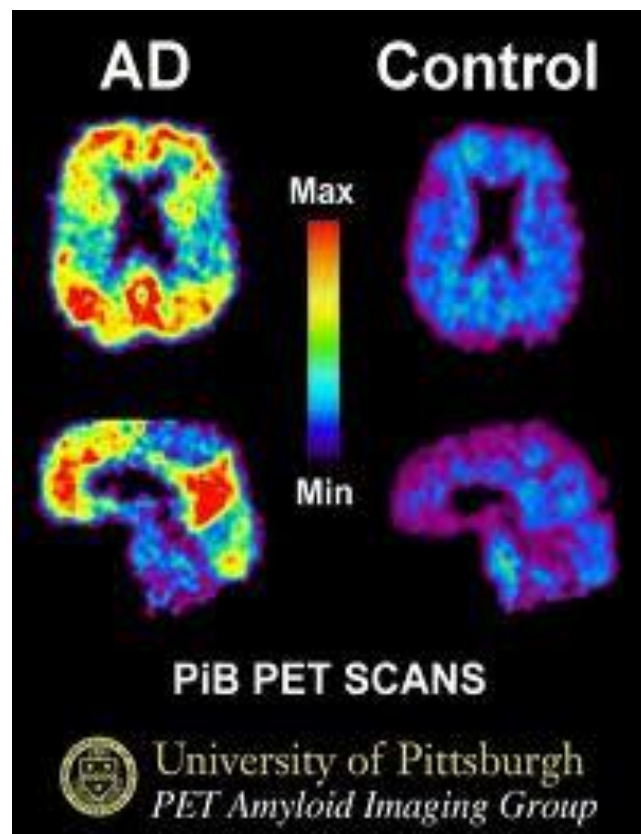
Comparison of SUV images from a control and an AD patients - University of Pittsburgh
